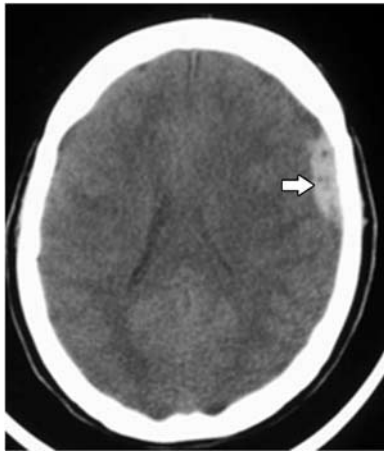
Computed tomography scan of a 39-year-old woman with Good posture syndrome and chronic renal failure on dialysis who presented with partial motor seizures, fever, headache, confusion, and vomiting. It shows hyperdense extra-axial collection that was proved to be staphylococcal subdural empyema after surgical evacuation.
